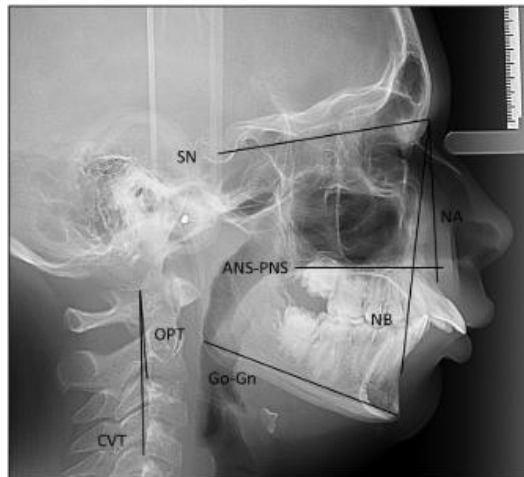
Reference lines on the cephalometric radiograph (Aglarci, 2016)
